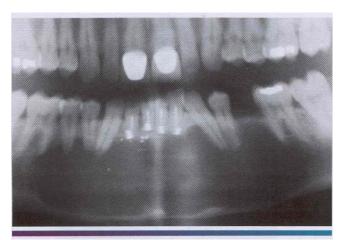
Figure $3\cdot 26$. Periapical cyst. Large unilocular radiolucency extending from the mandibular first molar to the contralateral first molar. (Courtesy of Dr. John R. Cramer.)
